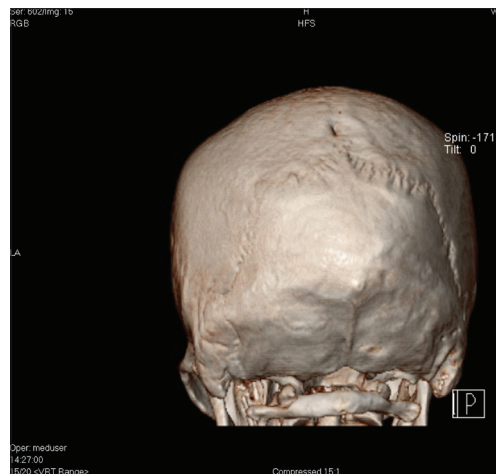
3D reconstruction of the skull using CT images. The midline calvarial defect is seen in the posterior parietal region as a depression indicating the site of the communicating tract
